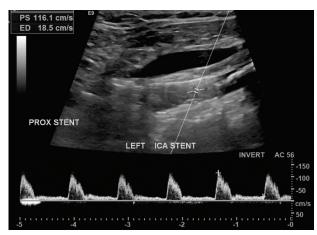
Follow-up duplex ultrasound confirming sustained vessel patency.
